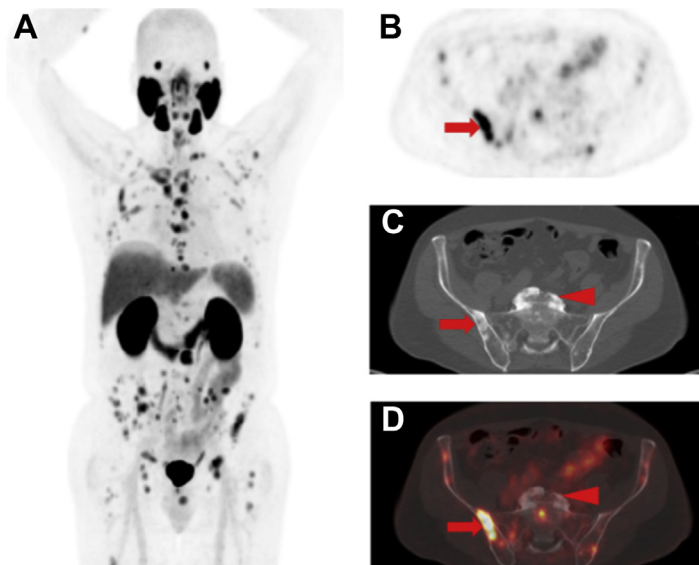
An 86-year-old man with extensive bone metastatic PCa. (A) MIP, (B) axial PET, (C) axial CT, and (D) axial PET/CT images from a PSMA-targeted ^{18}F -DCFPyL scan showing extensive abnormal uptake in the visualized skeleton. Note the intense uptake in sclerotic lesions consistent with bone metastases (red arrows), whereas there is no uptake in degenerative sclerosis (red arrowheads).
